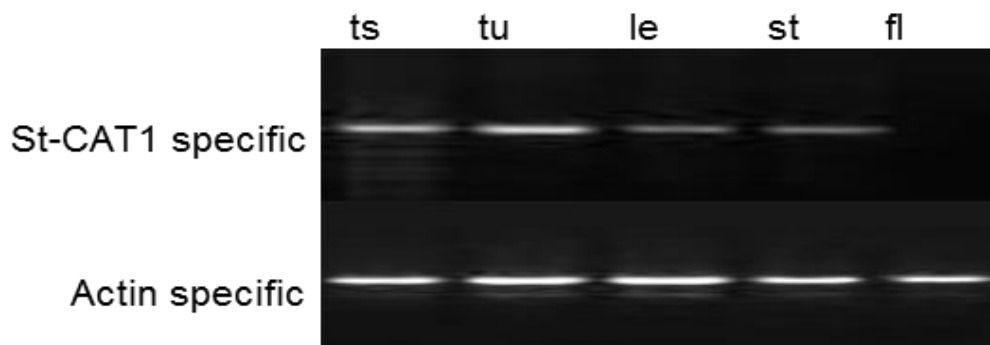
Semi-quantitative RT-PCR for *CAT1* gene expression analysis using total RNA from different potato organs (cultivar KC-1) and the primers F1-CT0001 and CT- R10403. ts tuberizing stolon, tu tuber, le leaf, st stem, fl flower. The size of the *CAT1*-specific amplified product was ~0.4 kb in ts, tu, le and st. Actin-specific primers were used as an internal control (the size of the amplified product ~0.65 kb in each organ).
